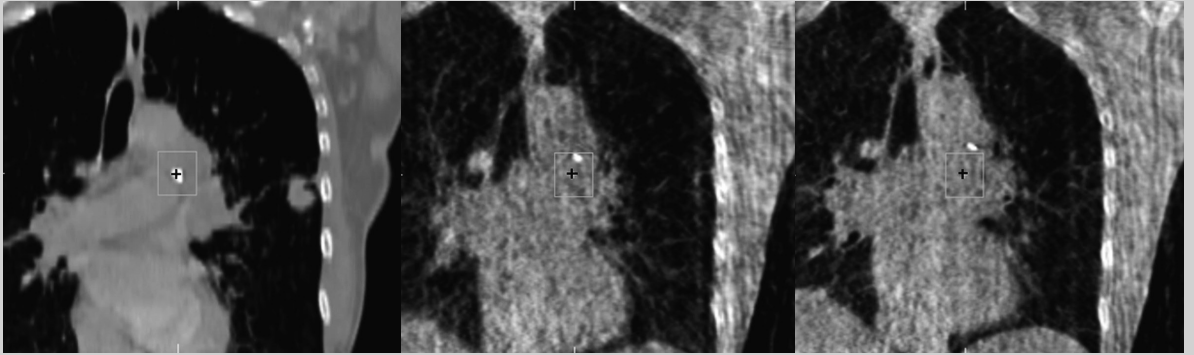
Example of marker baseline variation. The planning CT (left column) and CBCT (exhale middle column, inhale right column) registered to the bony anatomy depicted in coronal plane. The center of the mass of the marker in the planning CT is marked by a black marker to show the displacement on CBCT.
